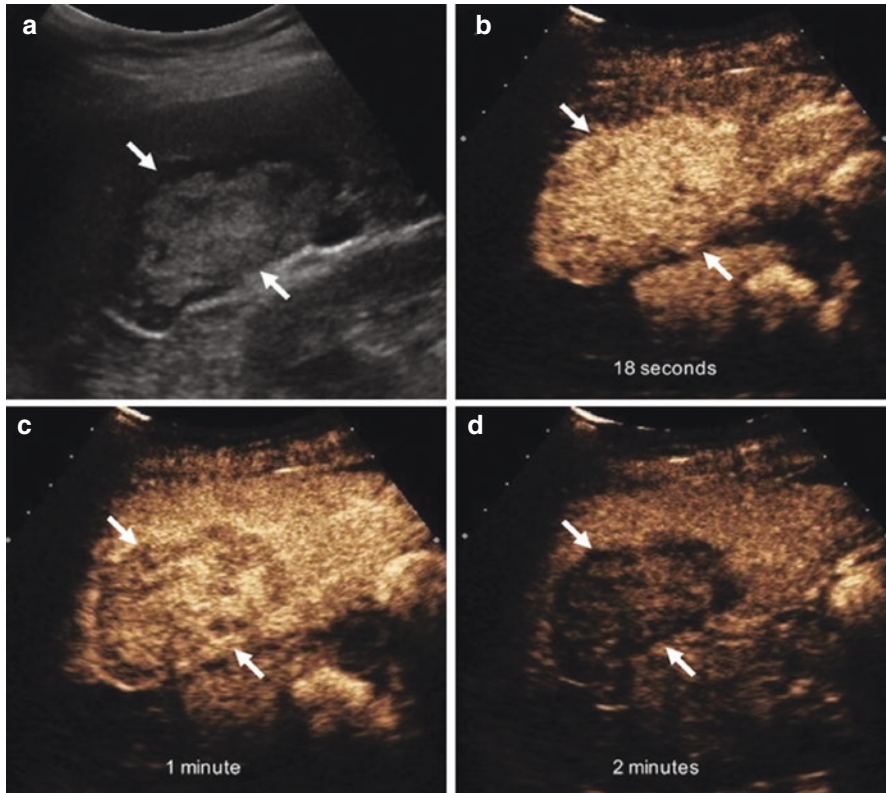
Ultrasonographic studies of intrahepatic cholangiocarcinoma: Sagittal B-mode image (a) shows a heterogeneous predominantly hyperechoic lesion with a hypoechoic halo (arrows) in the right liver lobe. Contrast-enhanced ultrasound (b–d) demonstrates that the lesion (arrows) has homogenous arterial phase enhancement (b), followed by early and heterogeneous washout in the portal venous phase within 60 s (c) as well as hypoenhancement in the late phase (d). (Reprinted by permission from SpringerNature: Durot et al. [37])
